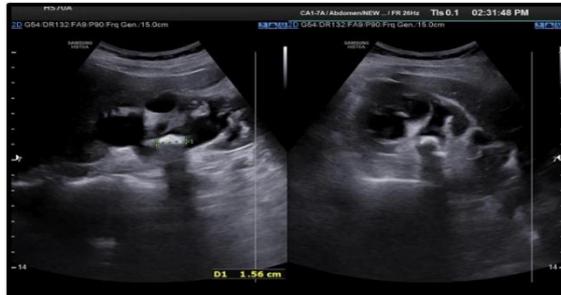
a. On ultrasound, Central pelvicalyceal system of right kidney appear moderately dilated with a high echogenic focus measuring 15.6 mm in right PUJ. b. On plain KUB x-rays film, there is an ill-defined radio-opacity noted in the right PUJ region. * Imaging features are likely suggestive of right PUJ calculus.
